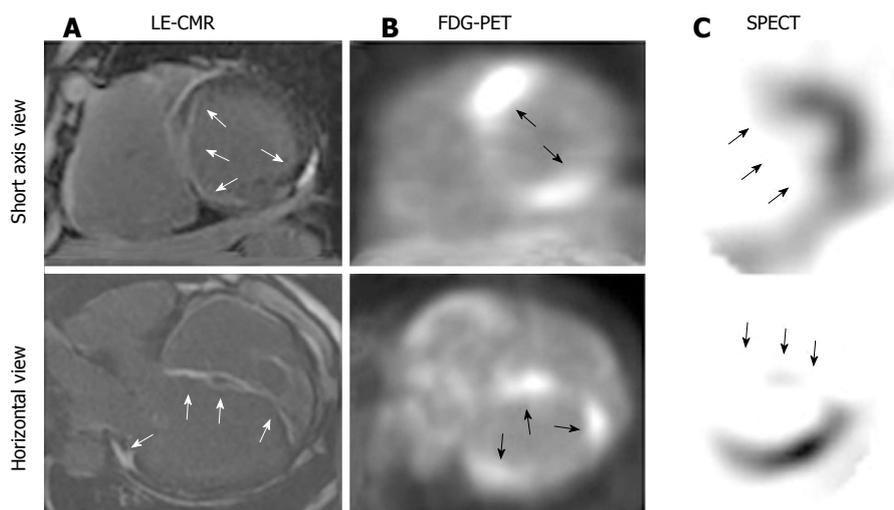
Non-invasive cardiac imaging in a 61-year-old male patient with cardiac involvement of systemic sarcoidosis. LE-CMR (A) shows diffuse LE in the subepicardium (RV side) and subendocardium (LV side) of basal to apical ventricular septum and patchy LE in the midwall of posterior LV (white arrows); Corresponding FDG-PET (B) demonstrates focal uptake in basal and apical ventricular septum and posterior LV wall (black arrows); ^{99m}Tc-sestamibi SPECT (C) exhibits a defect only in ventricular septum (black arrows). CMR: Cardiac magnetic resonance; FDG-PET: ¹⁸F-fluorodeoxyglucose-positron emission computed tomography; LE: Late gadolinium enhancement; LV/RV: Left and right ventricles; SPECT: Single photon emission computed tomography.
